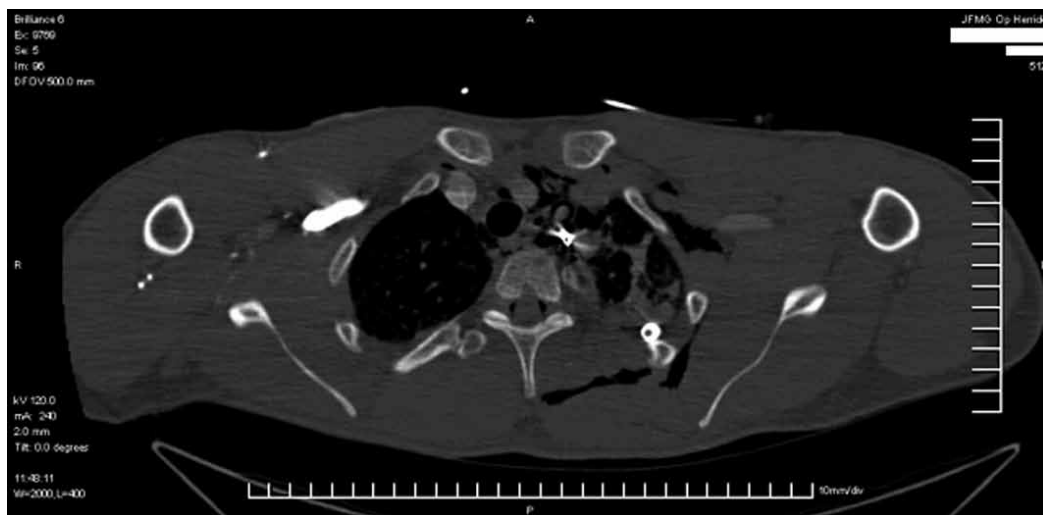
CT Scan of upper chest showing spinal air and retained round.
